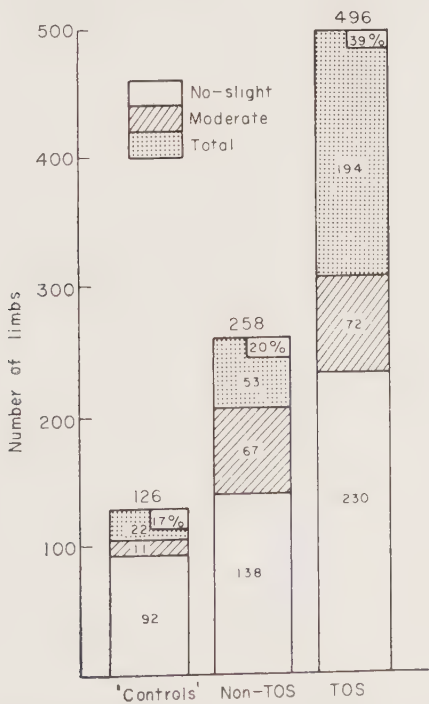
Arterial compression determined with Doppler-flowmetry in AER position in "controls", non-TOS and TOS patients. Numbers in columns refer to numbers of extremities and percentage total occlusion.
